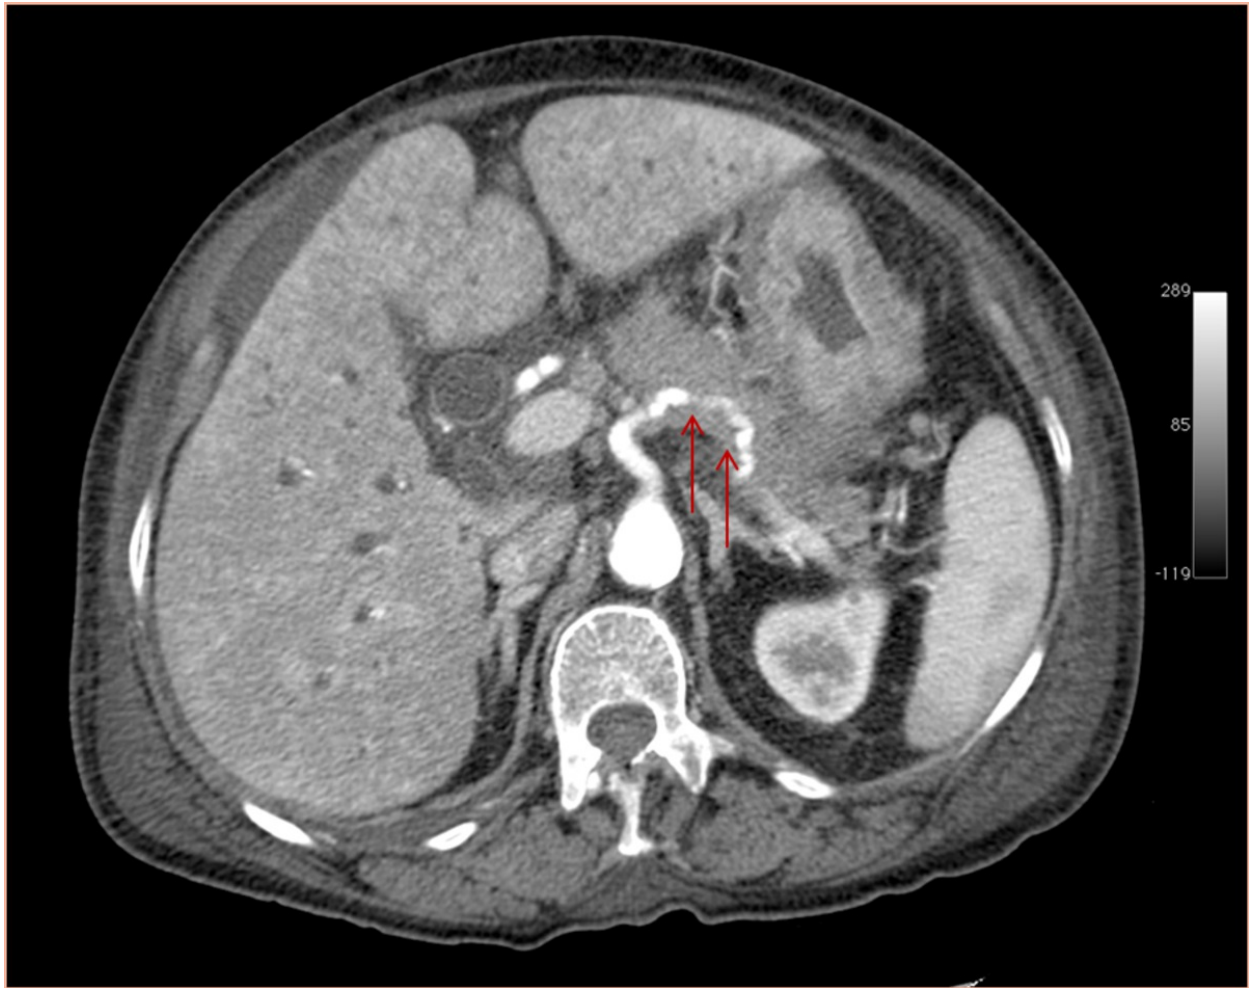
Enhanced axial CT image in pancreatic phase of a patient with a hypodense mass in pancreatic body, with pancreatic tail atrophy and signs of vascular encasement of the splenic artery (arrows).
